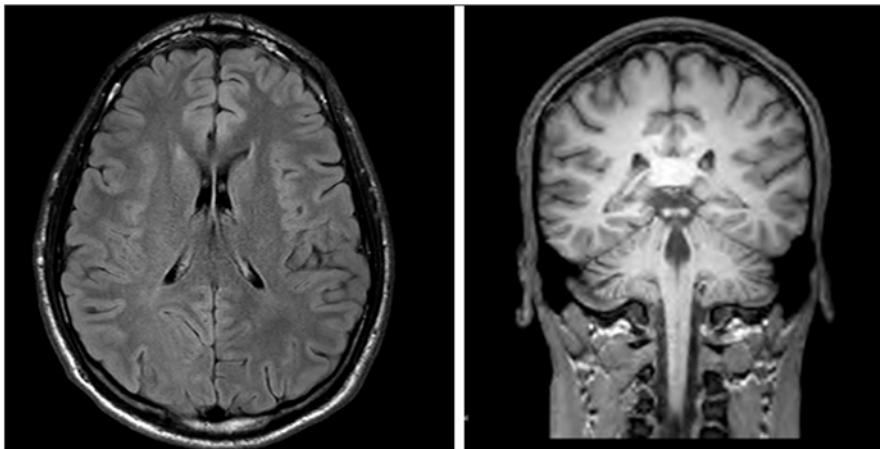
The ventricular system is in axis, of normal size. Seasonal liquids are standard for bed base and convexity. No pathological alterations of the overvoltage of supratentorial or subtentorial parenchymal signal are allowed except for a *minute hyperintensity signal (in FLAIR) precentral subcortical to the left of possible vascular genesis*. There are no obvious gross abnormalities in the Willis polygon vessels
